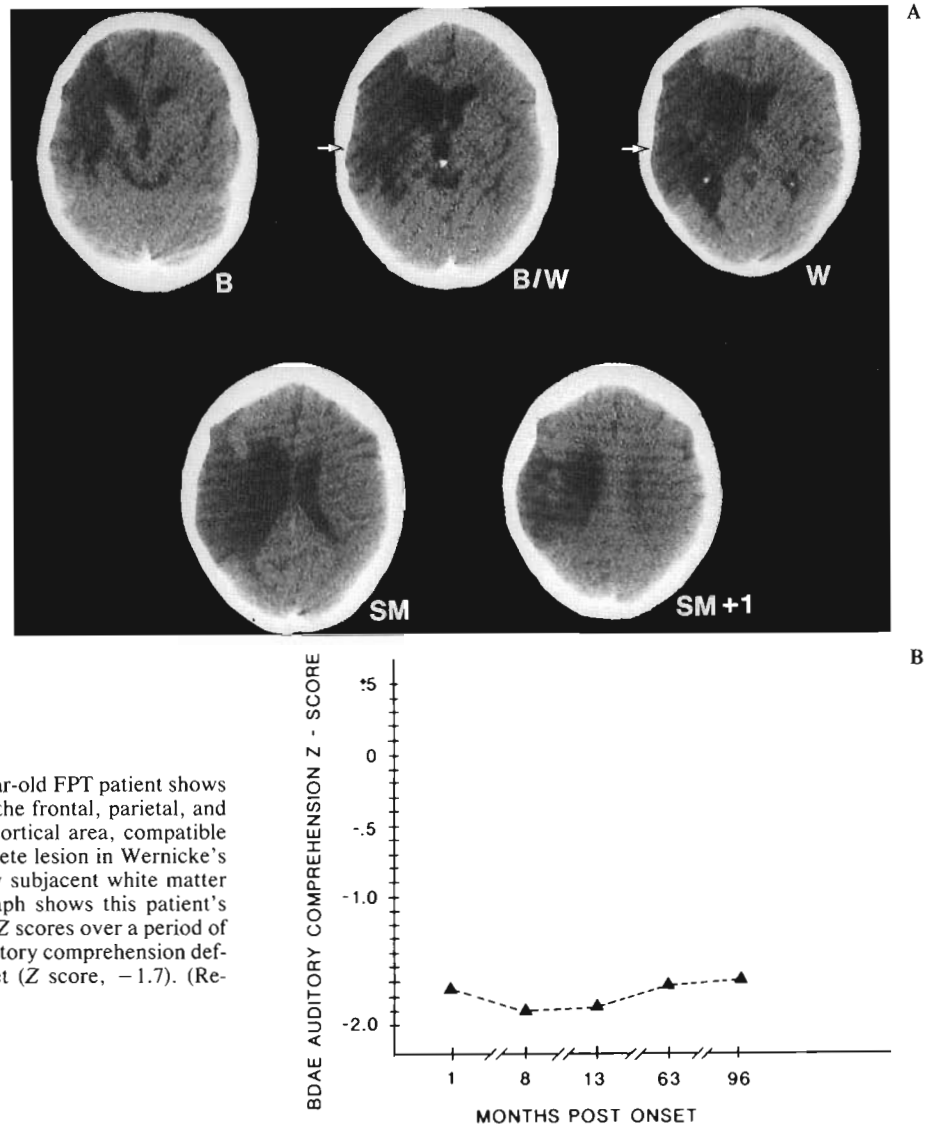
A: CT scan at 8 MPO of a 61-year-old FPT patient shows extensive cortical-subcortical lesion in the frontal, parietal, and temporal lobes, including Wernicke's cortical area, compatible with global aphasia. There was a complete lesion in Wernicke's cortical area, including the immediately subjacent white matter on slices B/W and W (arrows). B: Graph shows this patient's BDAE overall auditory comprehension Z scores over a period of several months postonset. A severe auditory comprehension deficit was still present 8 years post onset (Z score, -1.7). (Reprinted from Naeser et al., 1990.)
